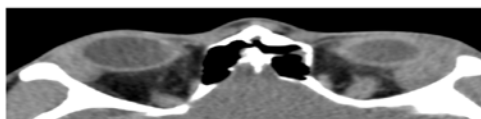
Axial CT image demonstrate bilateral asymmetrical enlargement of the lacrimal gland with involvement of both the orbital and palpebral portions.
